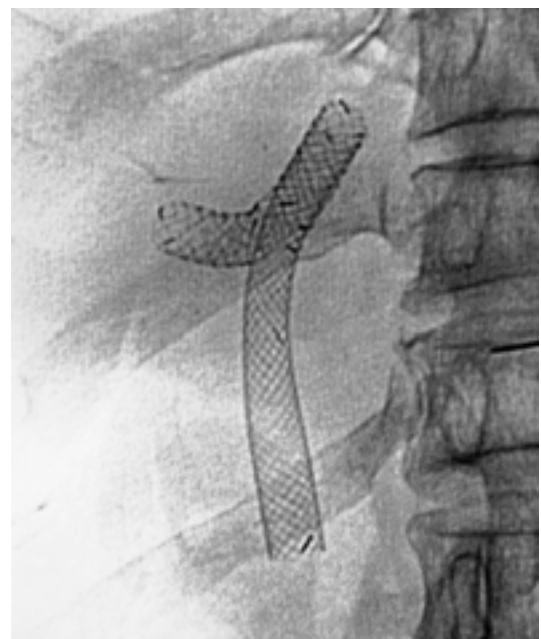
Plain radiograph shows the appearance of the T stent configuration.
